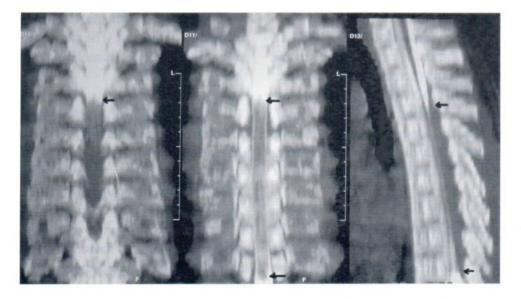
Curve coronal and sagittal reconstruction of CT myelography show the levels of the compression and extension of the lesion.
